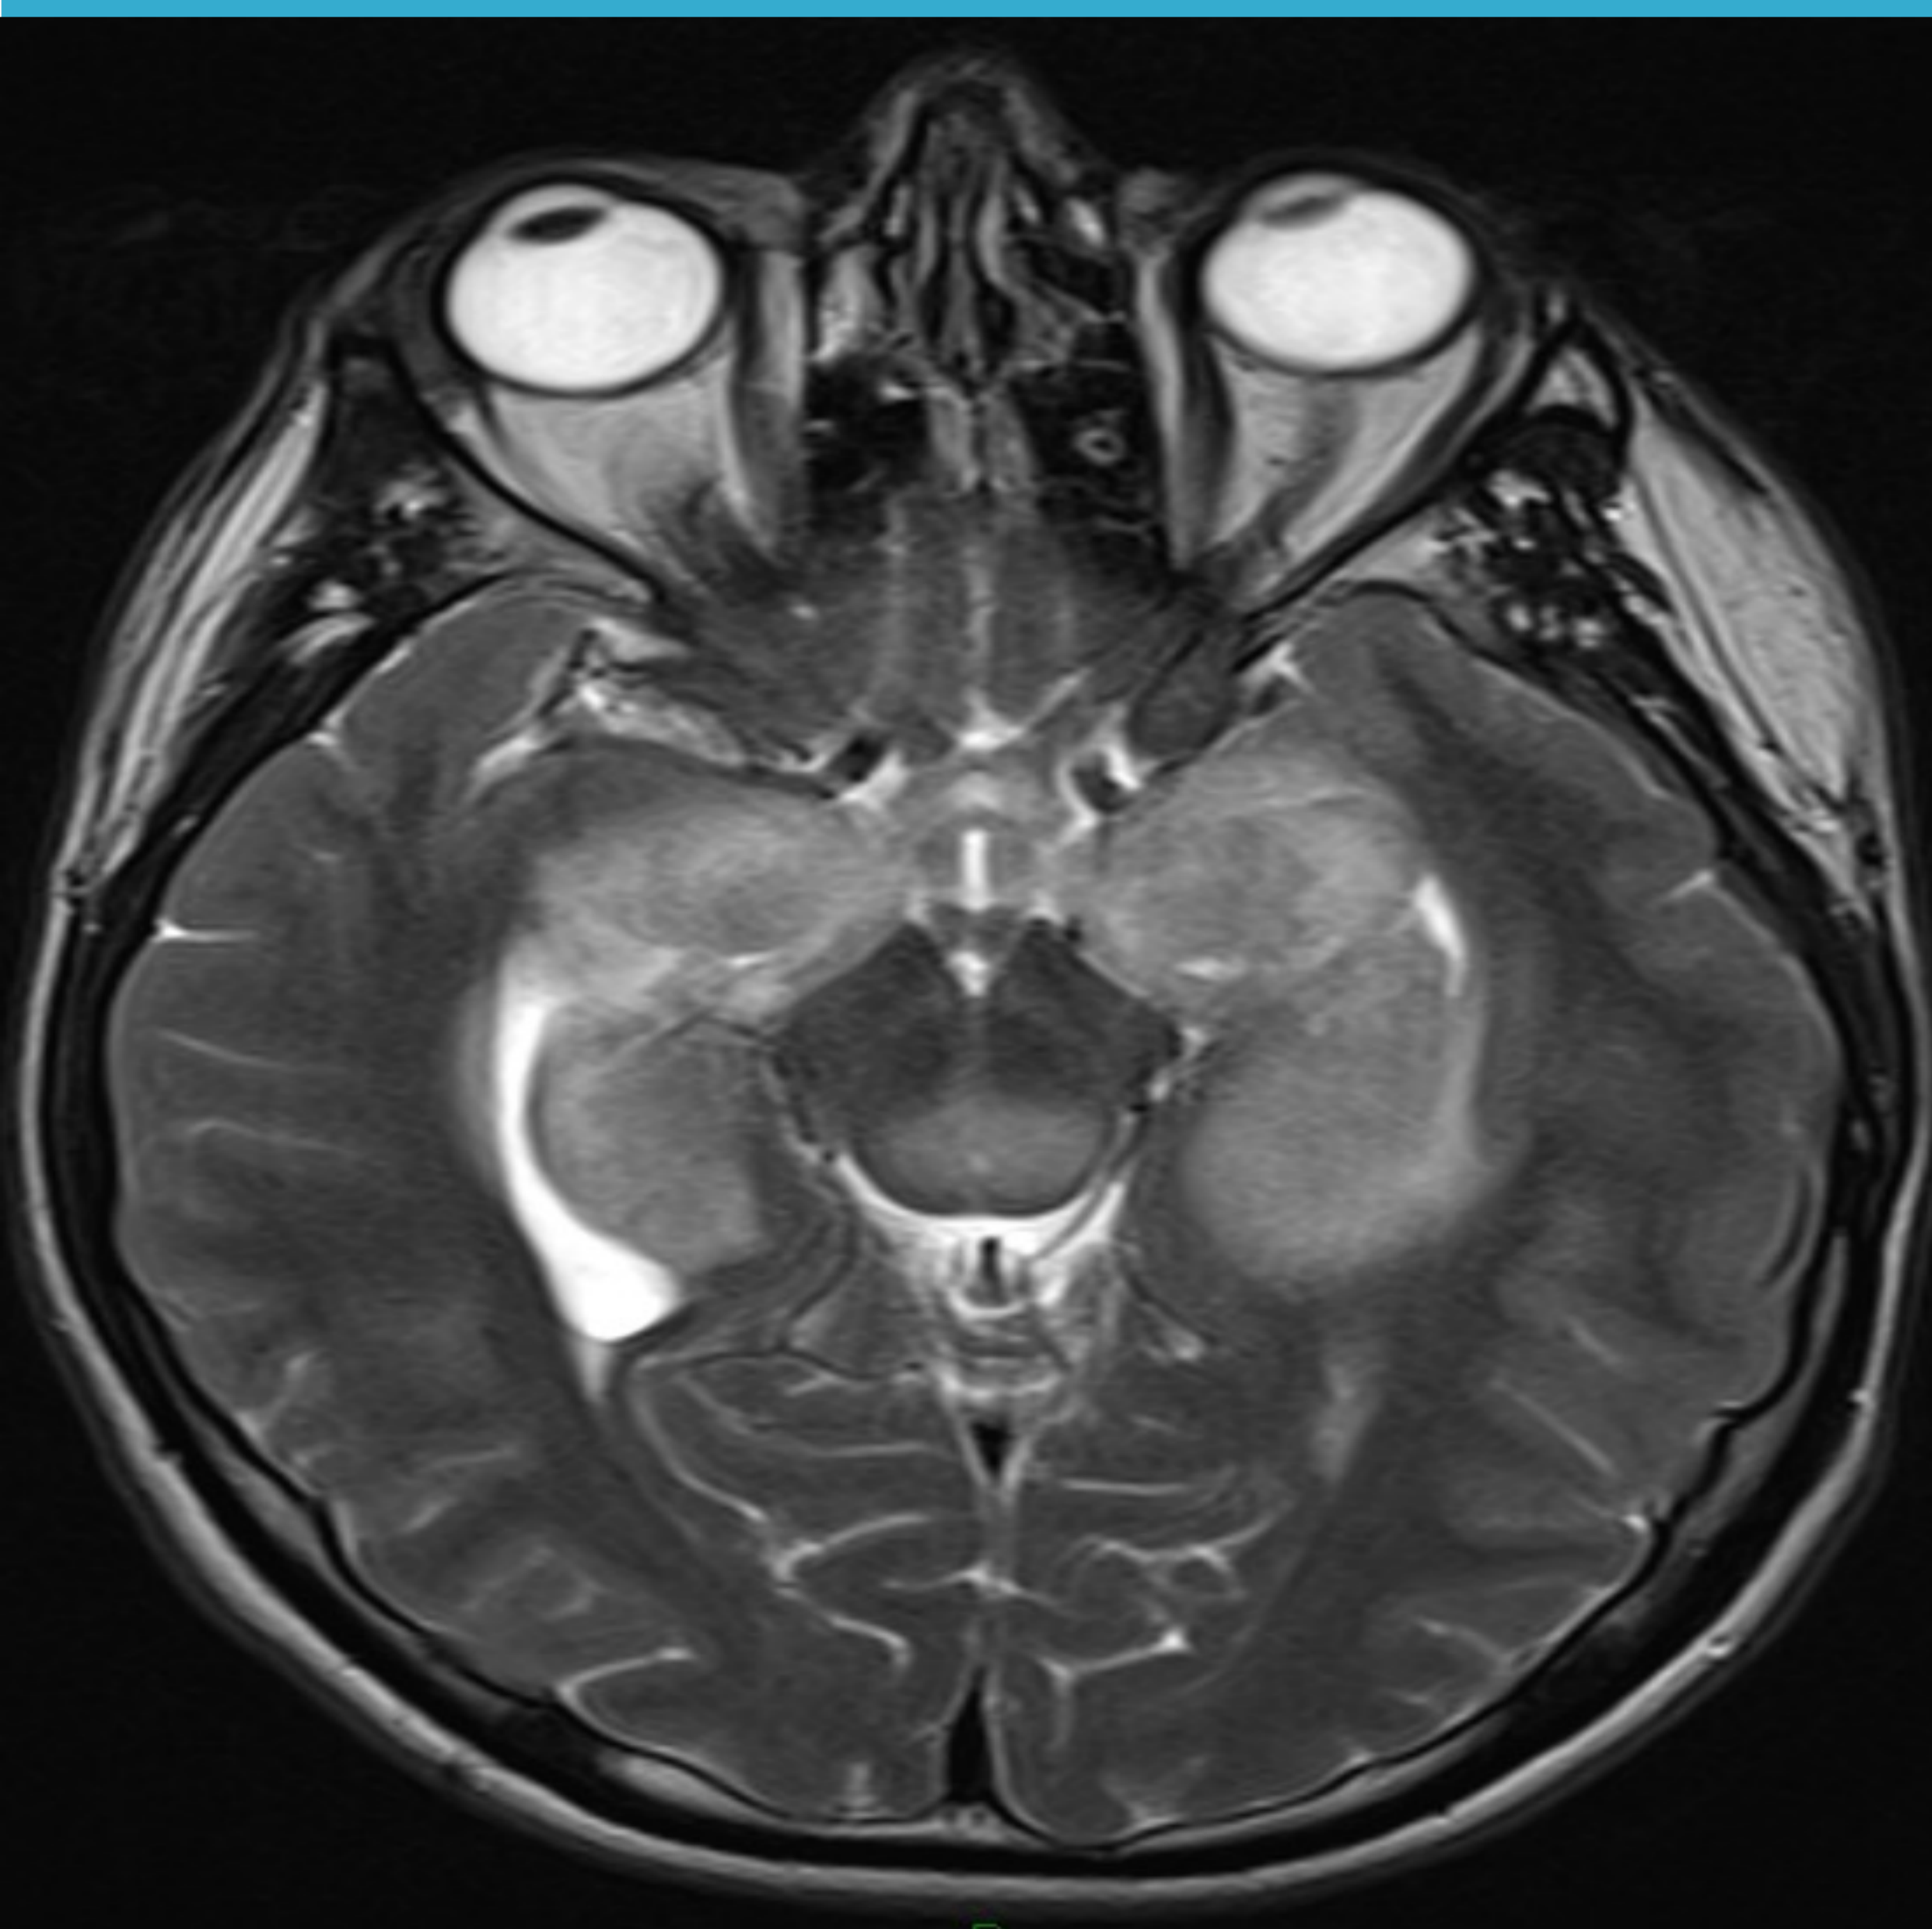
Initial MRI scan – August 2021
